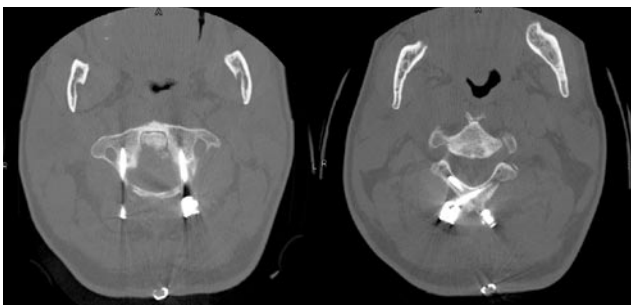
Postoperative axial computed tomography shows C1 lateral mass and C2 intralaminar screw placement.
